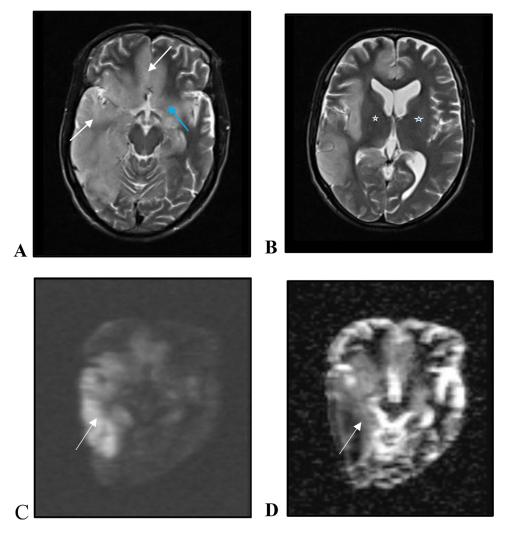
Axial non-contrast brain MRI, T2 (A&B), DWI (C) and ADC (D) shows the following findings: There is high T2 signal intensities with swollen gyrus and effacement of surrounding sulci in the right temporal lobe (indicated by short arrow), bilateral lower paramedian frontal lobes (indicated by long arrow) and left mesial temporal lobe (indicated by blue arrow) (A). bilateral basal ganglia remain unaffected (indicated by white stars) (B). (C) DWI and (D)ADC images demonstrate subtle restricted diffusion in the areas of the brain where the signal intensity changes are observed (white arrows).
